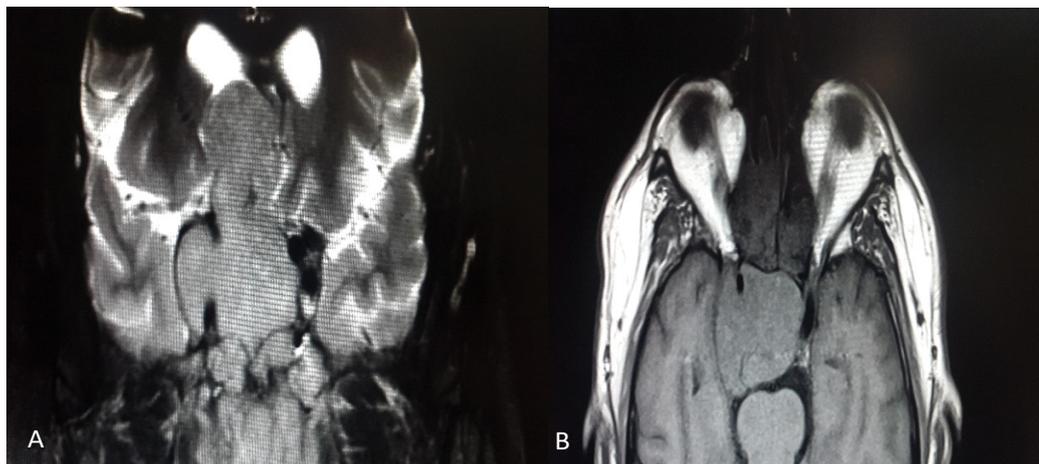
Synchronous squamous cell carcinoma with inverted papilloma T4B (A, B) MRI showing an extensive tumor with intracranial invasion. He under went treatment with CT + RT and died of local disease.
